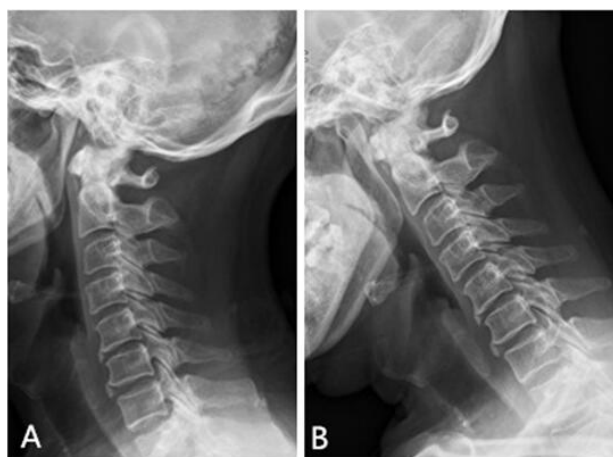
Preoperative Dynamic lateral cervical X-ray. C spine Flexion and Extension dynamic roentgenograms: Degenerative change, decreased disc height space at C3/4 level and Osteophytes at C3-4, C5-6. (A): Right Lateral-Extension View; (B): Right Lateral -Flexion View.
